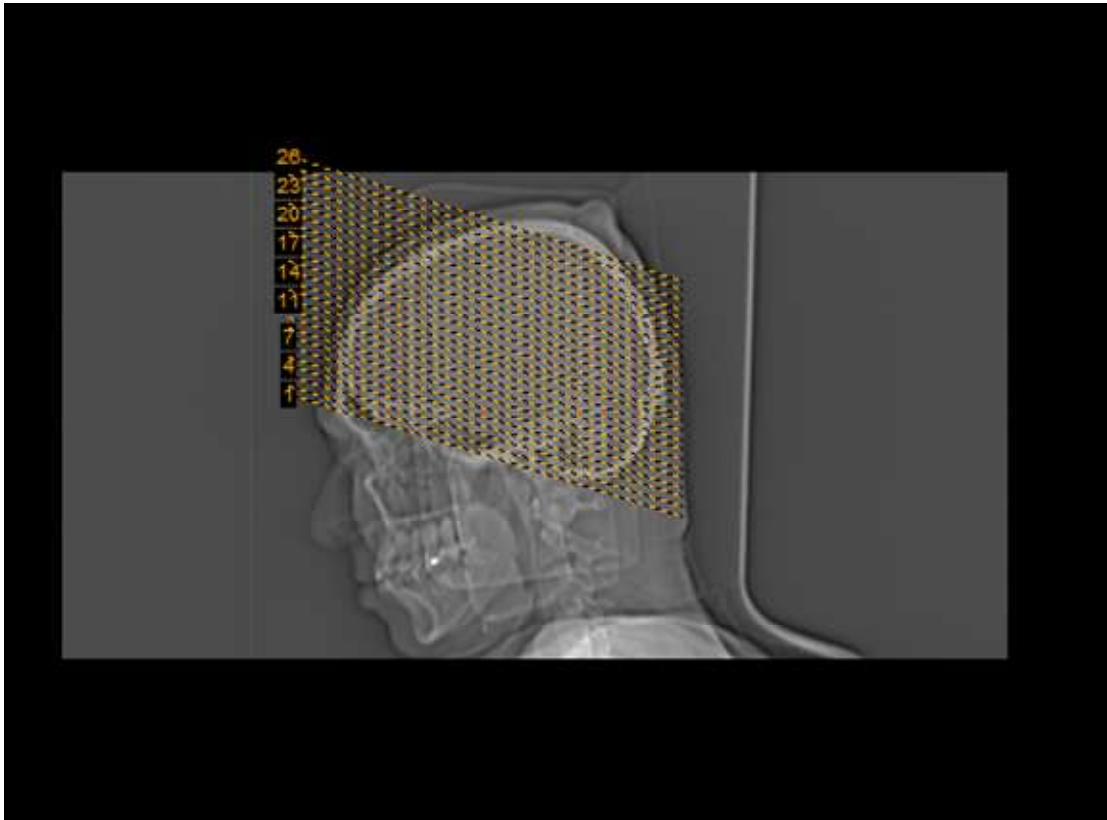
CT scan of brain. Topogram and Planning.
